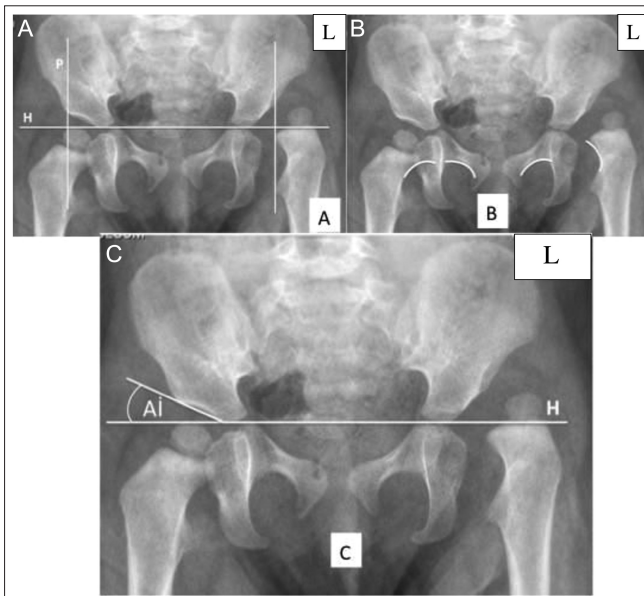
Radiological parameters used in the evaluation of developmental dysplasia of the hip. L, left. (A) Pelvis anteroposterior view (AP)x-ray. H, Hilgenreiner line; P, Perkins line. The femoral head has to be in the lower medial quadrant. On the x-ray, the left femoral head is dislocated. (B) Pelvis AP x-ray. The Shenton-Menard line is intact on the right side (normal hip) but broken on the left (dislocated hip). (C) Pelvis AP x-ray. AI, acetabular index; H, Hilgenreiner line.
